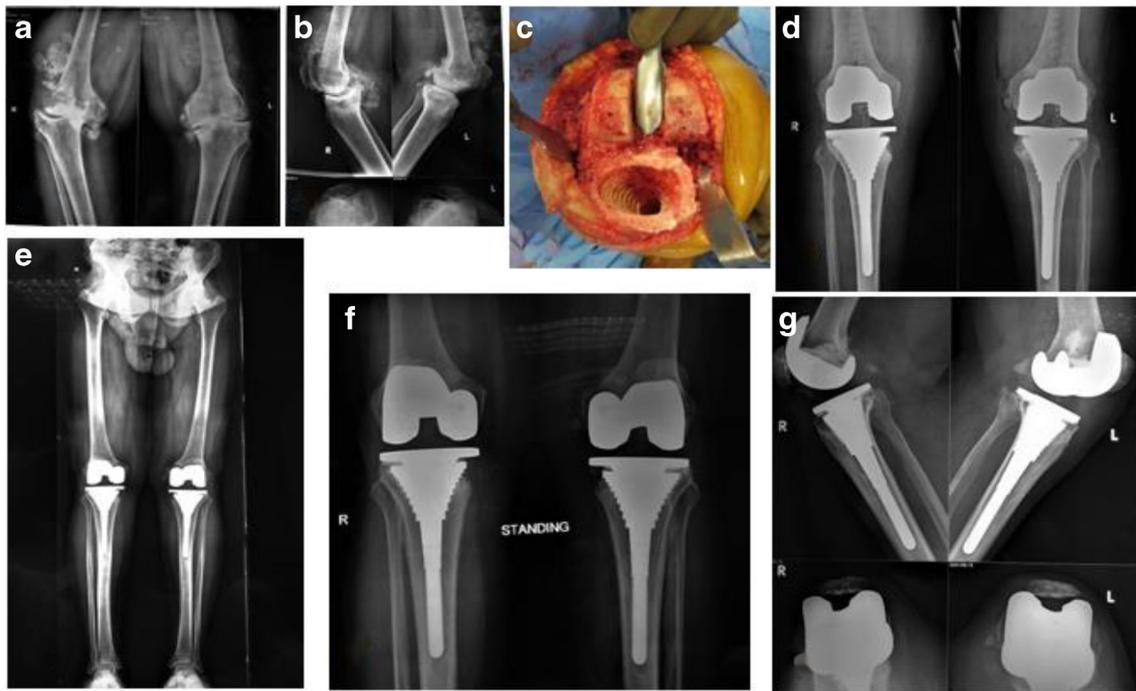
A & B) Anteroposterior & Lateral Radiographs with skyline view: Advance OA involving both knees with varus deformity, C) Intra-operative reaming of Tibia with medial loss of cortex, D) Post-op AP radiographs, E) Scanogram, D) AP, Lateral & Skyline radiographs after 1 year
